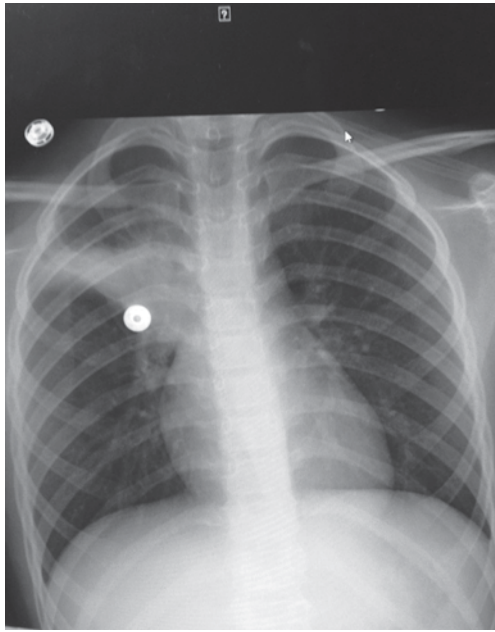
Nine-year-old female presents with cough and fever. Chest X-ray shows right upper lobe infiltrate
